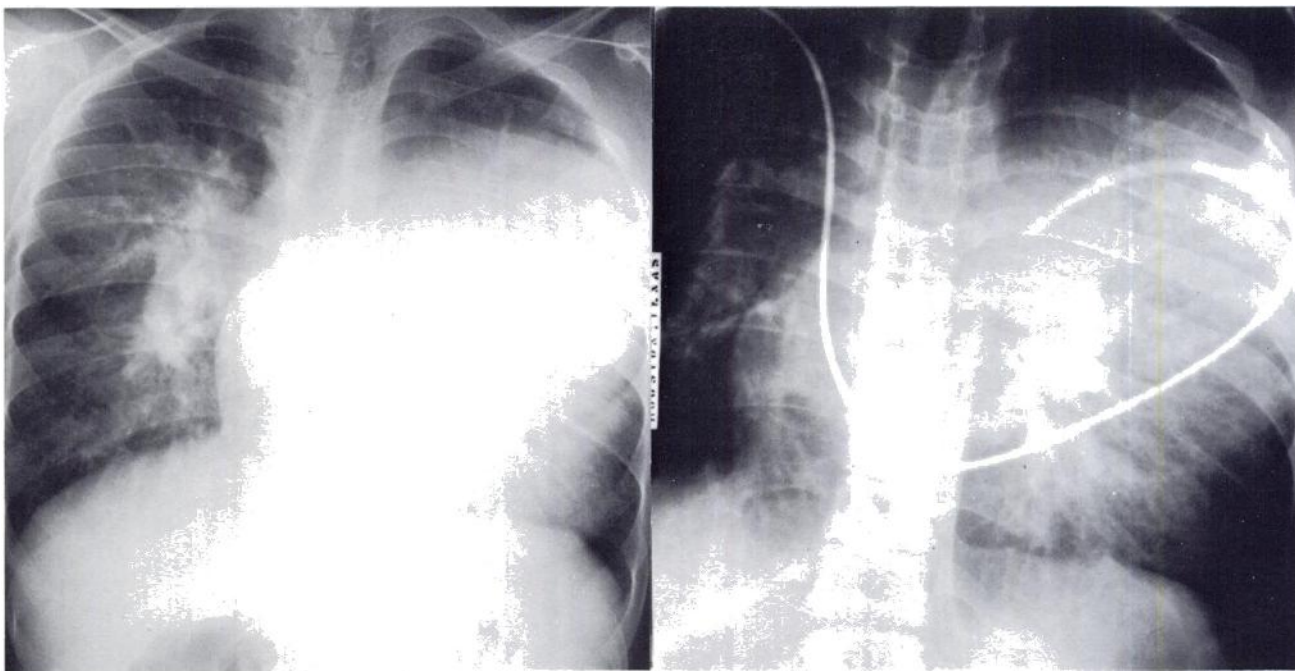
(Case 2). Chest roentgenogram showing dilatation of right pulmonary artery and large mass in left hemithorax. FIGURE 4 (Case 2). Chest roentgenogram disclosing angiocatheter coursing through right atrium and right ventricle before entering main pulmonary artery. Essentially all of catheter to left of spine lies within large saccular aneurysm of left main pulmonary artery.
